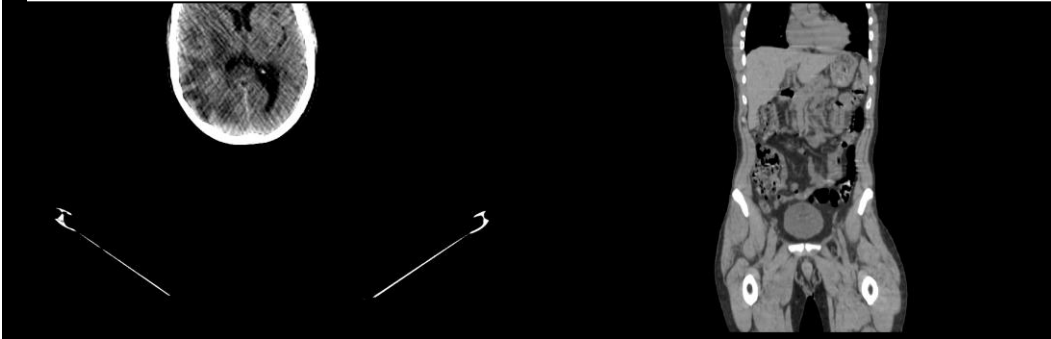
Concomitantly acquired CT images for attenuation correction and localization. The low density area in the right parietal lobe is consistent with vasogenic edema which surrounds the mass which is isodense to the brain parenchyma.
